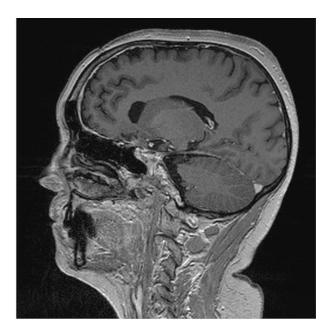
Axial and sagittal reconstructions of a contrast-enhanced MRI scan of the patient from Clinical case 2, 1 month postoperatively.
